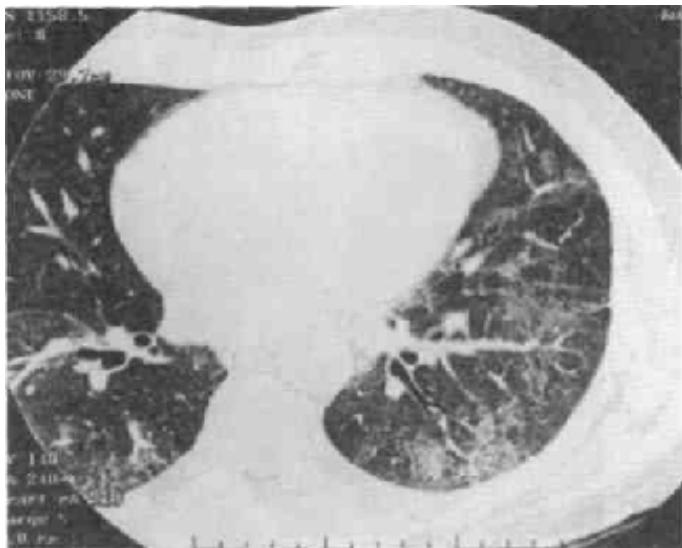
Nonspecific interstitial pneumonia – HRCT.
